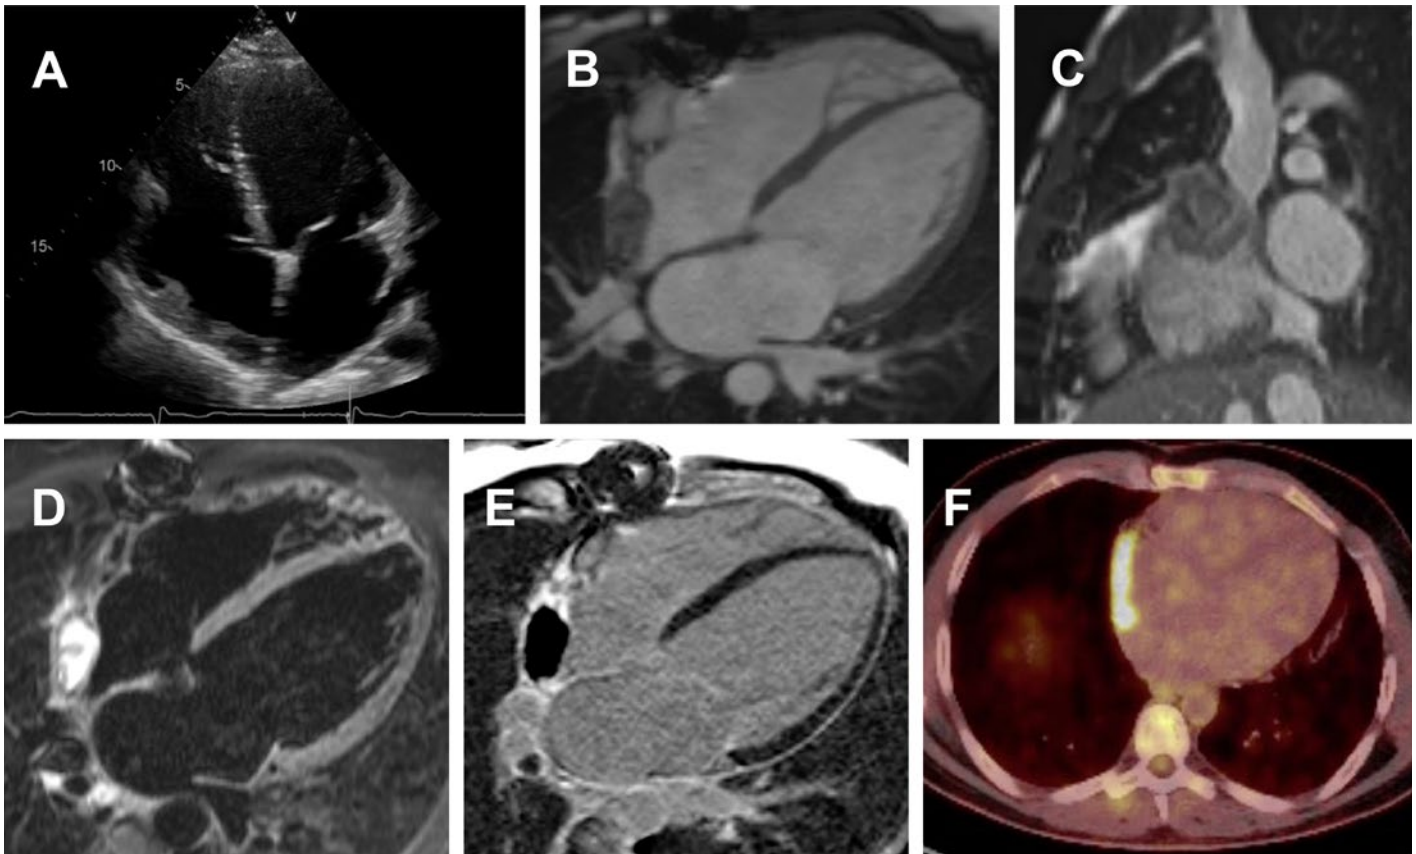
Echocardiography, CMR and PET images 6 months after tumor resection suggestive for a local relapse. (A) transthoracic echocardiography showing new a thickened right atrial wall, (B–E) repeated CMR demonstrating again a right atrial cystic mass near the entrance of the superior vena cava with irregular contrast medium uptake and a large cystic or necrotic central area, (F) PET-CT revealed abnormal high uptake in this area suggestive for a tumor relapse.
